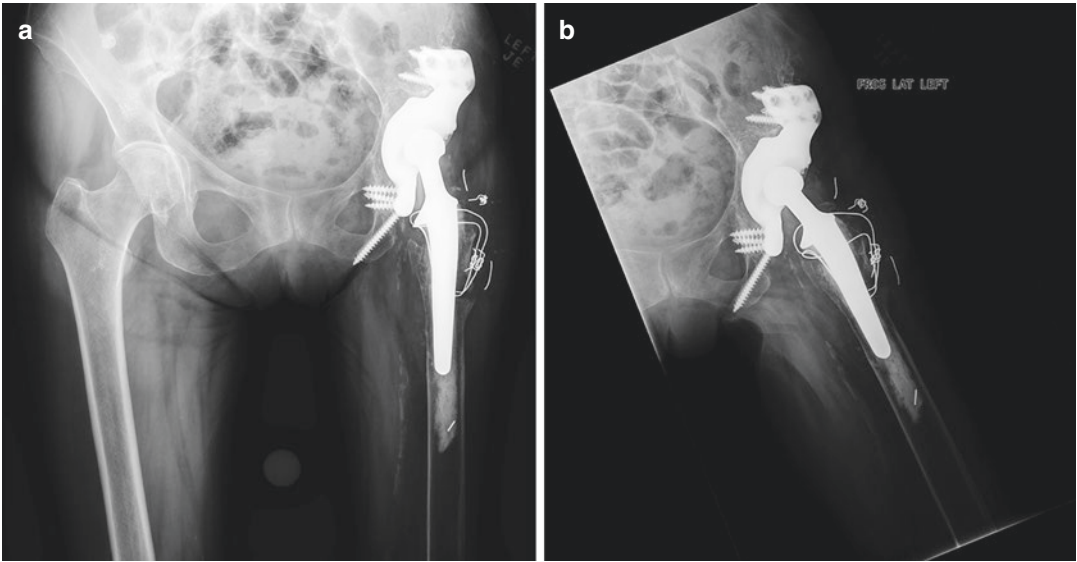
(a, b) Postoperative AP pelvis and frog lateral radiographs demonstrating revision THA using a custom tri-flange implant for acetabular reconstruction, and retention of the original femoral stem
